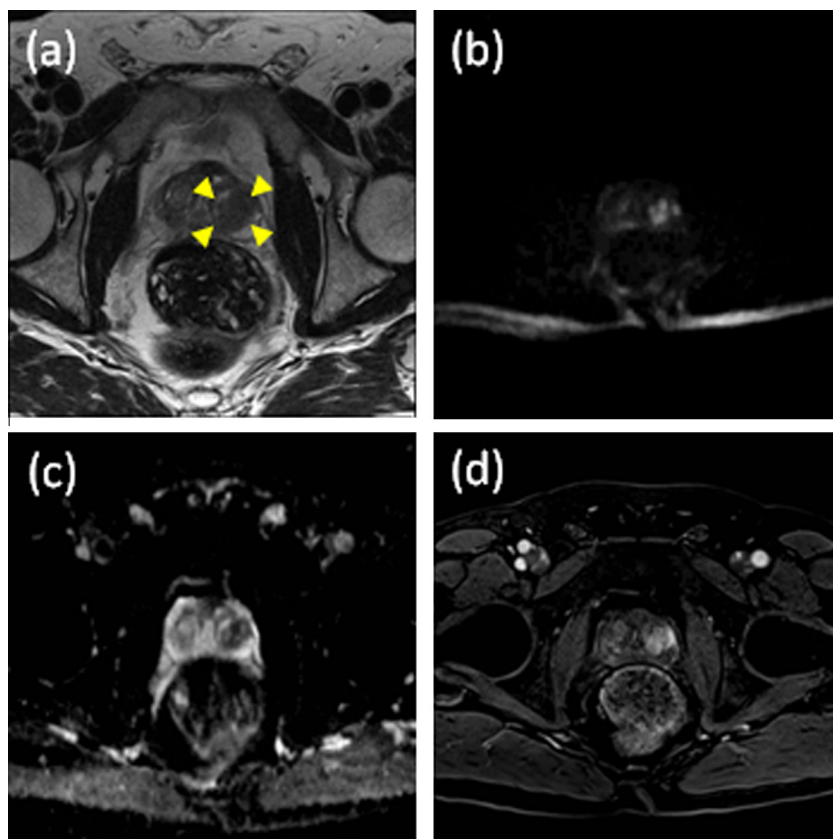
Axial multi-parametric MR images from the prostate patient ((a) T2 weighted, (b) $b = 1400 \text{ s/mm}^2$ DW image, (c) Apparent diffusion coefficient map, and (d) early post contrast T1 DCE). Yellow arrows indicate the area of peripheral zone prostate cancer. (For interpretation of the references to colour in this figure legend, the reader is referred to the web version of this article.)
